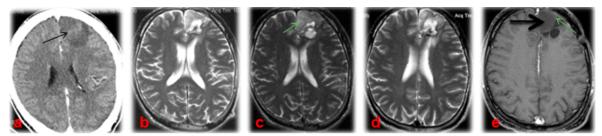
A. Computer tomography with contrast enhancement show a izointense lesion without contrast enhancement without mass effect and surrounded by edema, B. MRI T2 axial image hyperintense area in the left frontal lobe at 4 months postoperatively and after radiotherapy, C. MRI exam at 12 months T2 axial shows a stable hyperintense lesion in the left frontal pole surrounded by minimum edema (arrow), D. T2 axial at 30 months the lesion is stable with disappearance of edema, E. MRI exam at 52 months T1 with contrast enhancement show a hypointense lesion (thick arrow) in the left frontal pole and a thin rim of contrast enhancement (thin arrow)
